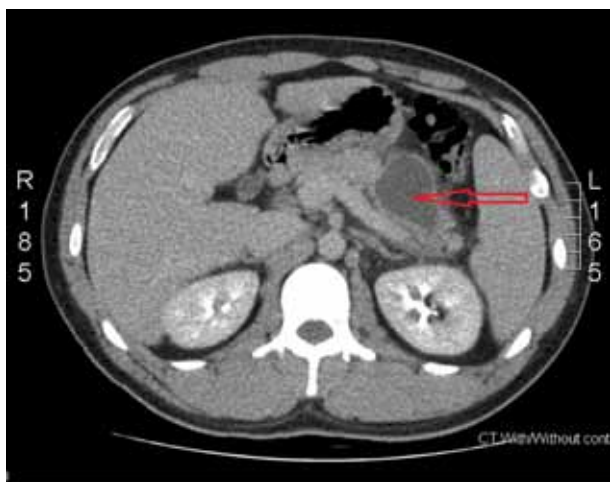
Abdominal CT showed a pancreatic tail pseudocyst (arrow).
